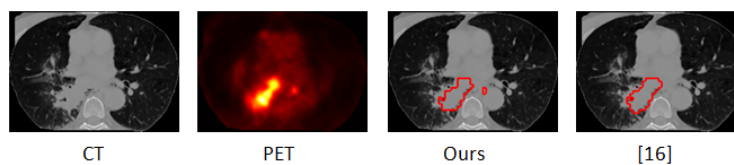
Example results showing that our method was more effective in detecting lesions with relatively low FDG uptake when compared to [11].
